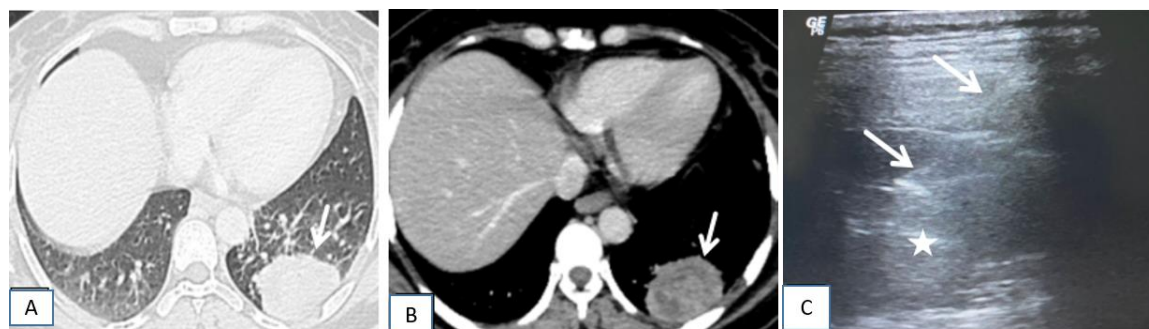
(A) CT lung window. (B) mediastinal window shows left lower lobe posterior basal segment peripheral mass lesion (arrow). (C) TUS high frequency liner probe B-mode image shows heterogeneous hypochoic lesion (star). Tru-cut needle (arrows) is seen within the lesion.
